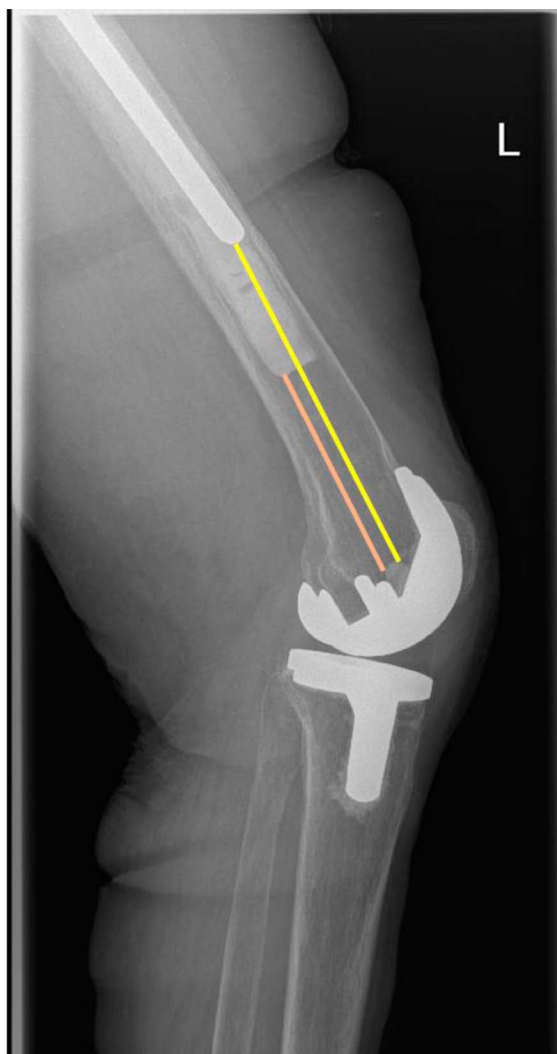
Radiographic measurement of the stem-to-stem distance (yellow) and the empty native bone distance (red) is shown in a patient undergoing a primary TKA.
